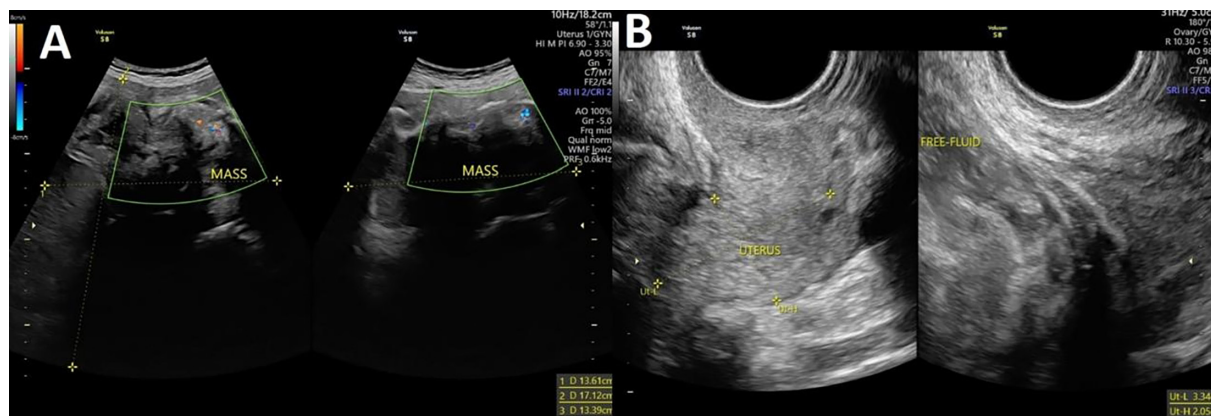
(A) Transabdominal ultrasound showing right ovarian cystic mass. (B) Transvaginal ultrasound showing right ovarian cystic mass.
